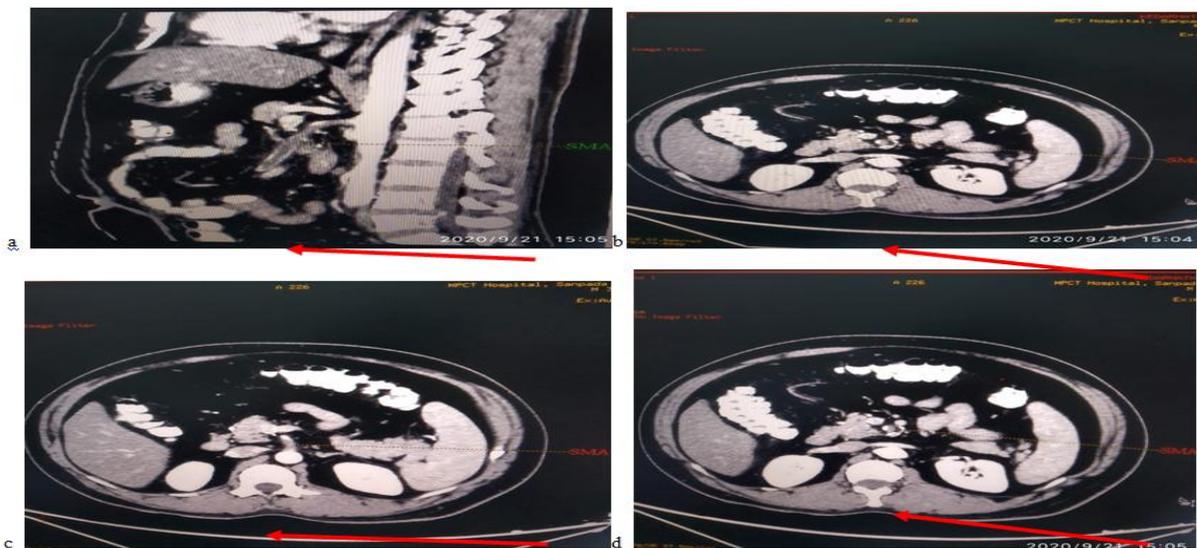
Contrast-enhanced computed tomography (CECT) reveals a hypodense lesion, suspected thrombus (arrow) in the main trunk of the superior mesenteric artery (a) in sagittal view. Axial section (b)(c) (d) suggest that the thrombus is located in the main trunk of SMA at the level of the second branch of the jejunal artery (arrow).
